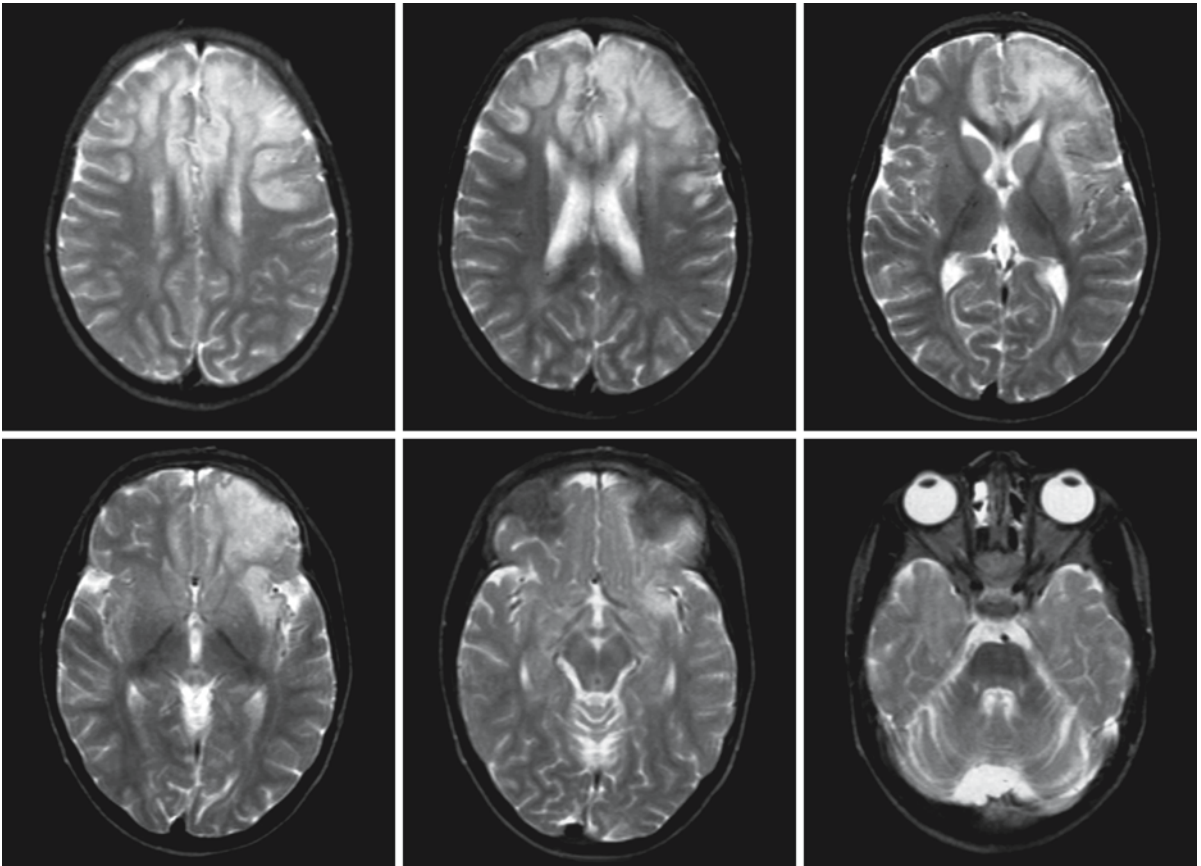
A boy, 6 years of age, with hyperargininemia. The MR images were made during an episode of acute metabolic decompensation following protein-rich gavage feeding. The T₂-weighted transverse images show the signal changes bilaterally in the frontal lobes, accentuated on the left side, with involvement of both gray and white matter, blurring the gray-white matter junction. The corpus callosum is not involved, nor are the basal ganglia
